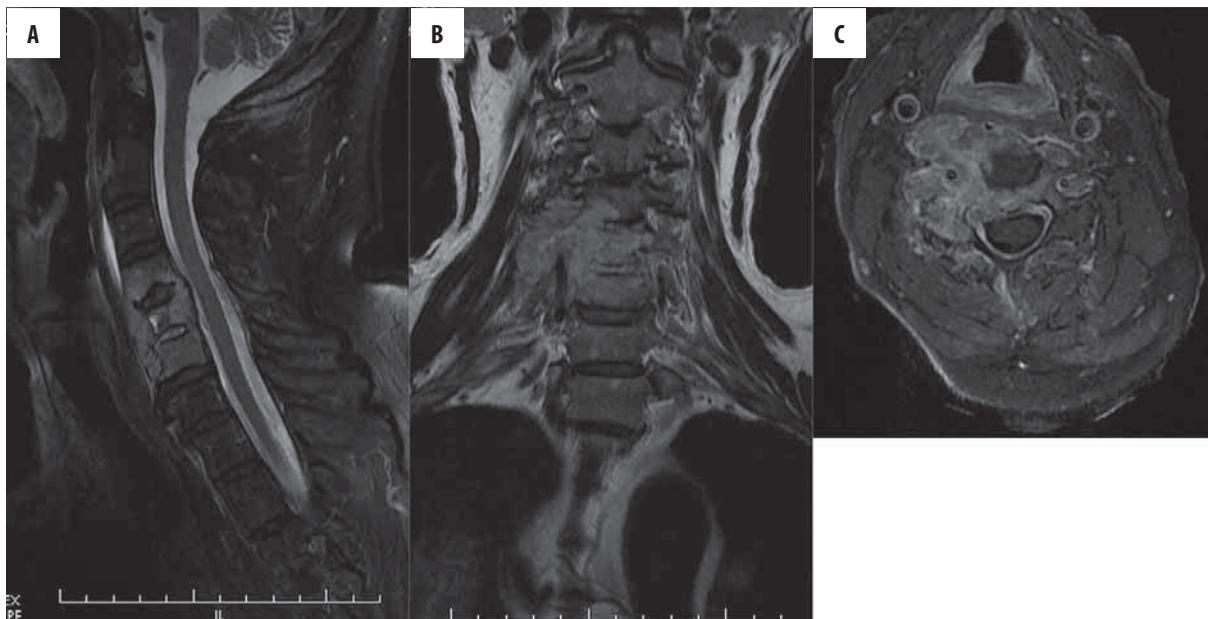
Diffuse neoplastic infiltration of the vertebral and paravertebral area. MRI: sagittal T2-weighted fat-suppression sagittal (A), coronal T1-weighted post-contrast (B) and axial T1-weighted fat-suppression post-contrast images very precisely demonstrate the extent of infiltration in the vertebrae, spinal canal, intravertebral foramina, and paravertebral soft tissue, including the brachial plexus area.
